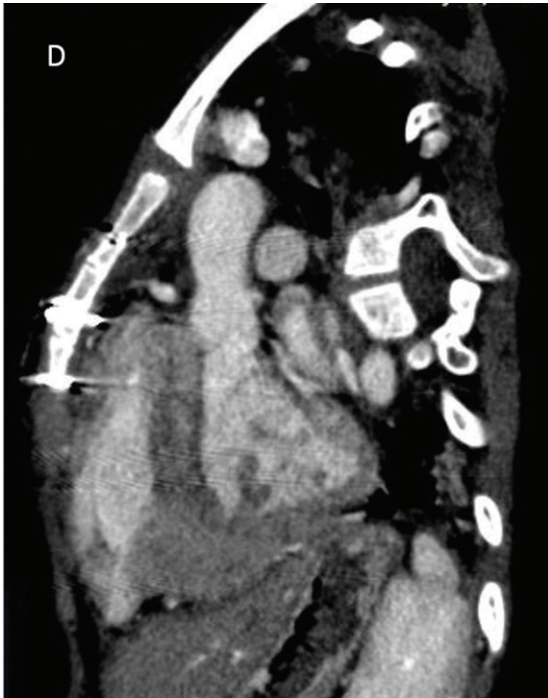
Postoperative CT (left ventricular outflow).
